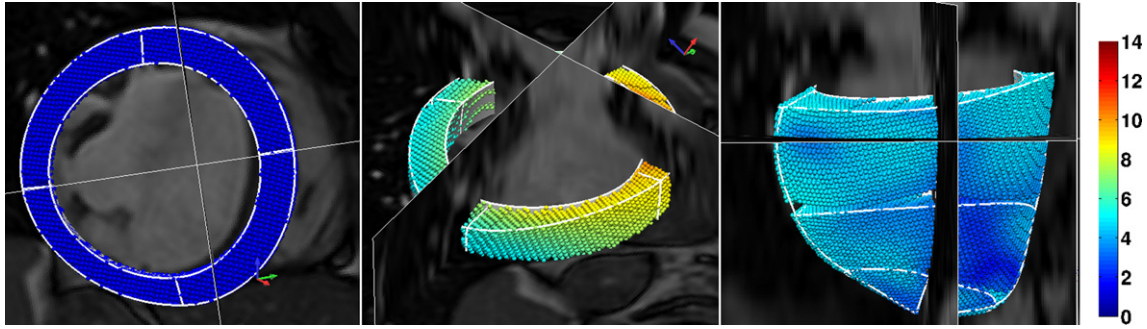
Results of dynamic meshing stage in Fig. 1 (the diseased case 1, visualized with the cine MRI from different views, corresponding to frames 1, 9 and 17 in a heart cycle starting with R wave). For visualization purpose, the mesh is shown together with the cine MRI. However, the meshes are reconstructed from the displacements of data points (embedded in the mesh) extracted from the combined tagged and cine MRI. The color represents the magnitude of displacement referencing to end-diastole in mm. (For interpretation of the references to color in this figure legend, the reader is referred to the web version of this article.)
